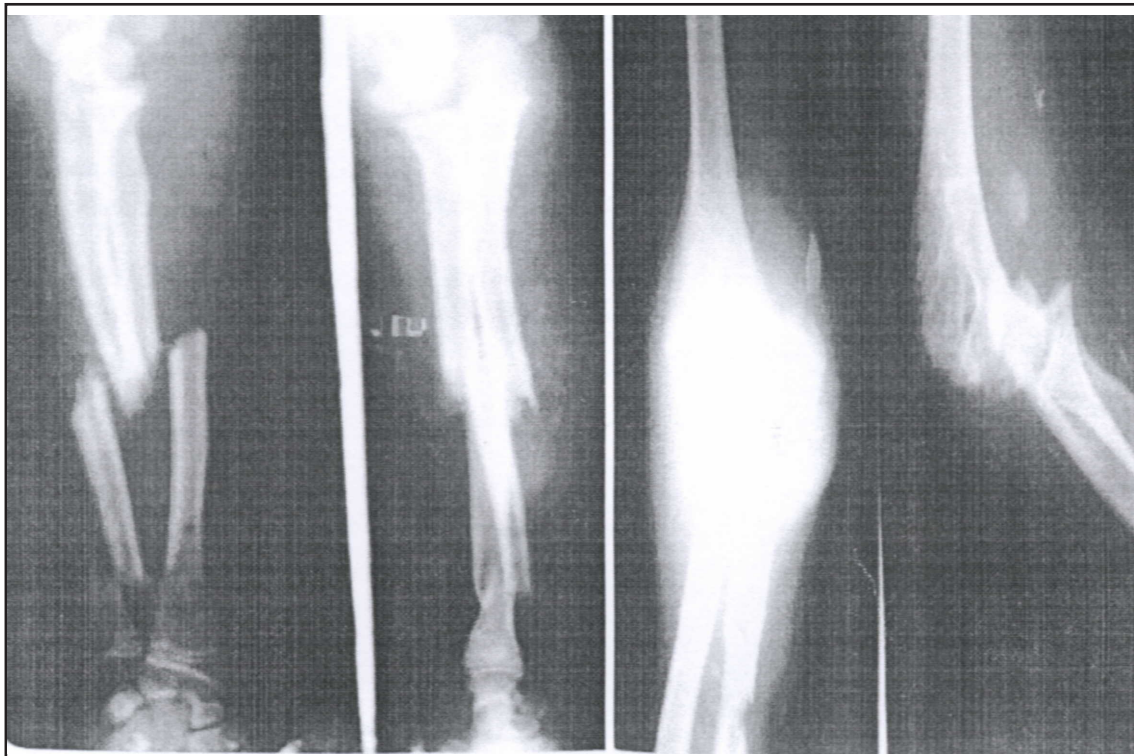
Pre-operative radiographs showing segmental fractures and complex fracture dislocation of elbow.
